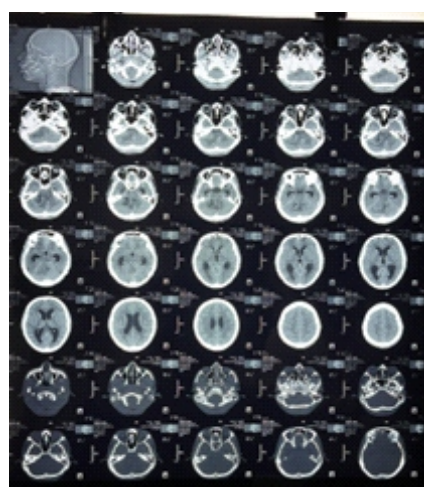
(b): HRCT right temporomastoid
